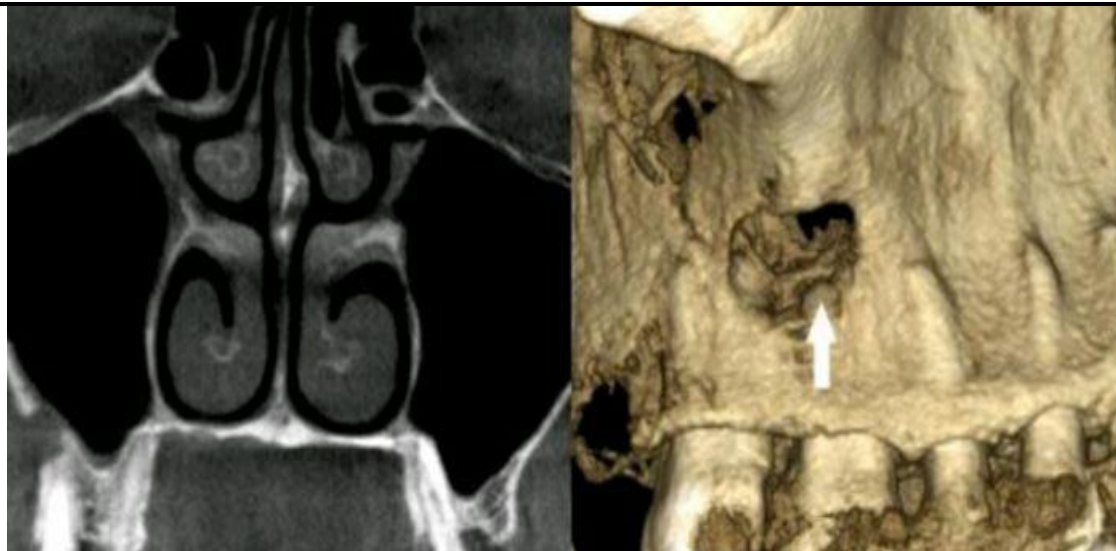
Patient H., 40 years old. CBCT. Condition after micromaxillotomy on the right. Left coronal projection – paranasal sinuses without pathology; right sagittal projection – arrow points to bone defect after micromaxillotomy.
